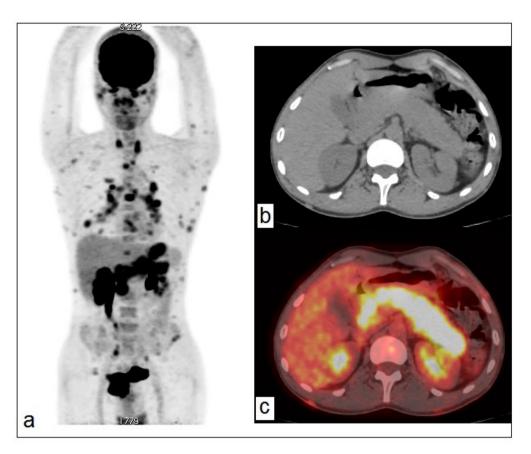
FDG-PET/CT Maximum intensity projection (a), transaxial CT image (b) and transaxial FDG-PET/CT image (c) showed enlarged pancreas and increased FDG uptake in head and body of the pancreas, and disseminated cutaneous, nodal, and solid organ FDG-uptake.
